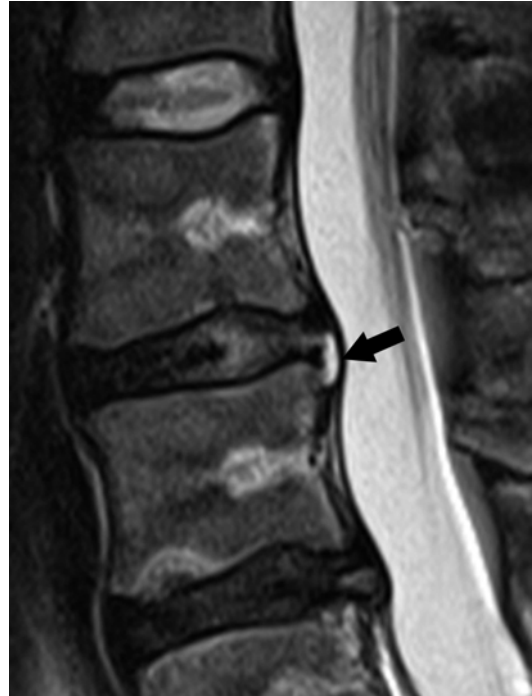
Multilevel disk degeneration with L2/L3 posterior hyperintense zone (HIZ) on sagittal T2w MR image (arrow). L3/L4 level demonstrates posterior disk bulge
